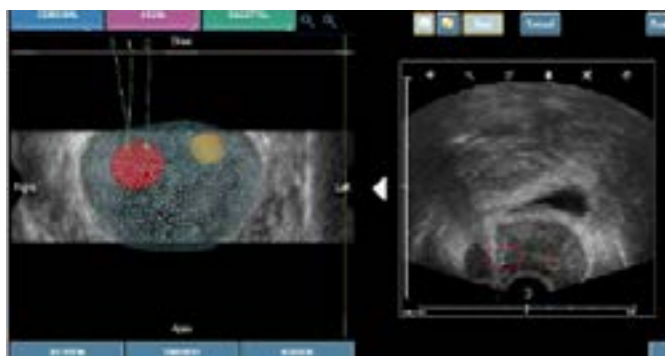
Targets' contour for the targeted biopsy on the US/PET-CT Fusion
